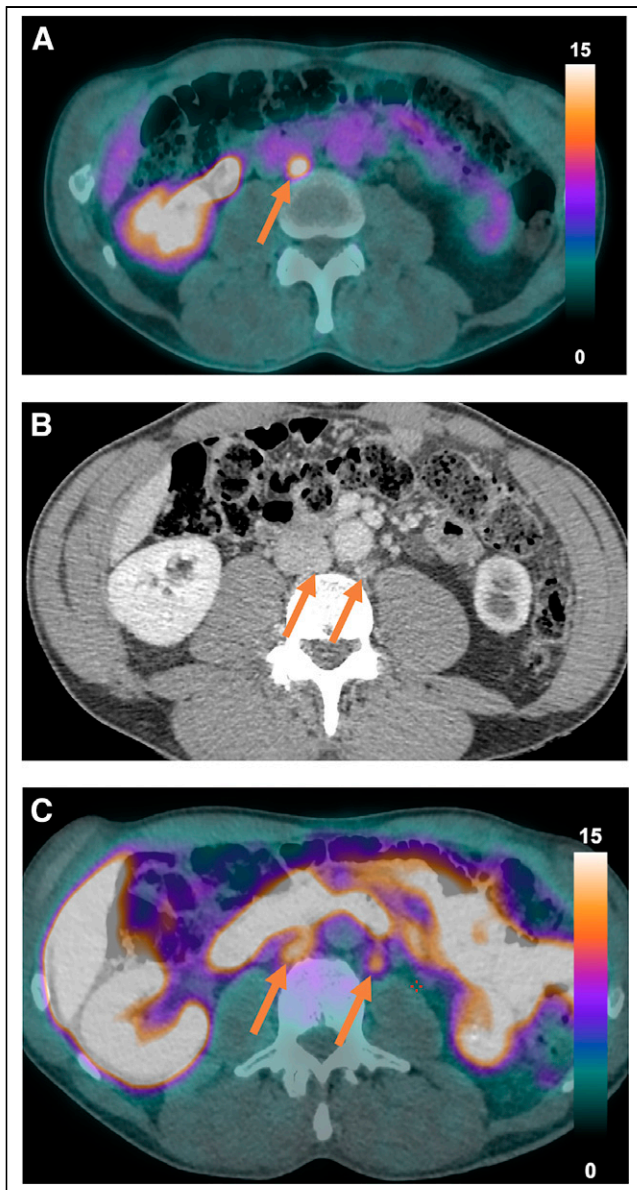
Lymph node status on ^{18}F -FDG PET/CT (A), ceCT (B), and $^{64}\text{CuCl}_2$ PET/CT (C). Paracaval node showed uptake of both tracers, whereas paraaortic node accumulated $^{64}\text{CuCl}_2$ but not ^{18}F -FDG (arrows). Uptake intensity is expressed in SUV.
